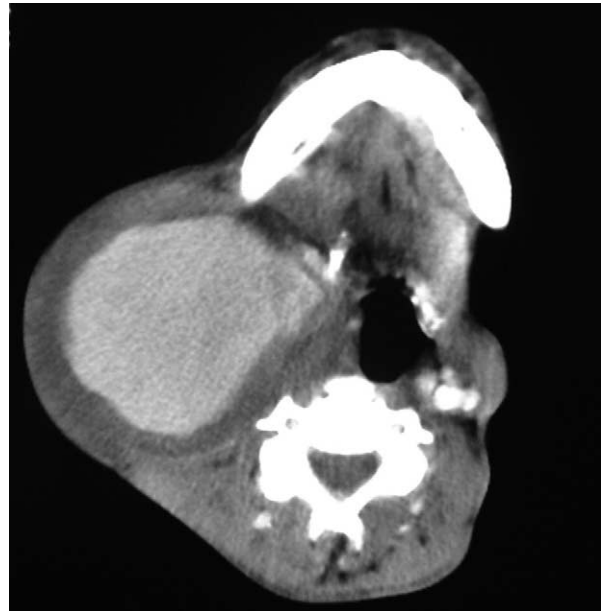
Computed tomographic scan of the neck showing an aneurysm of the right common carotid artery.
